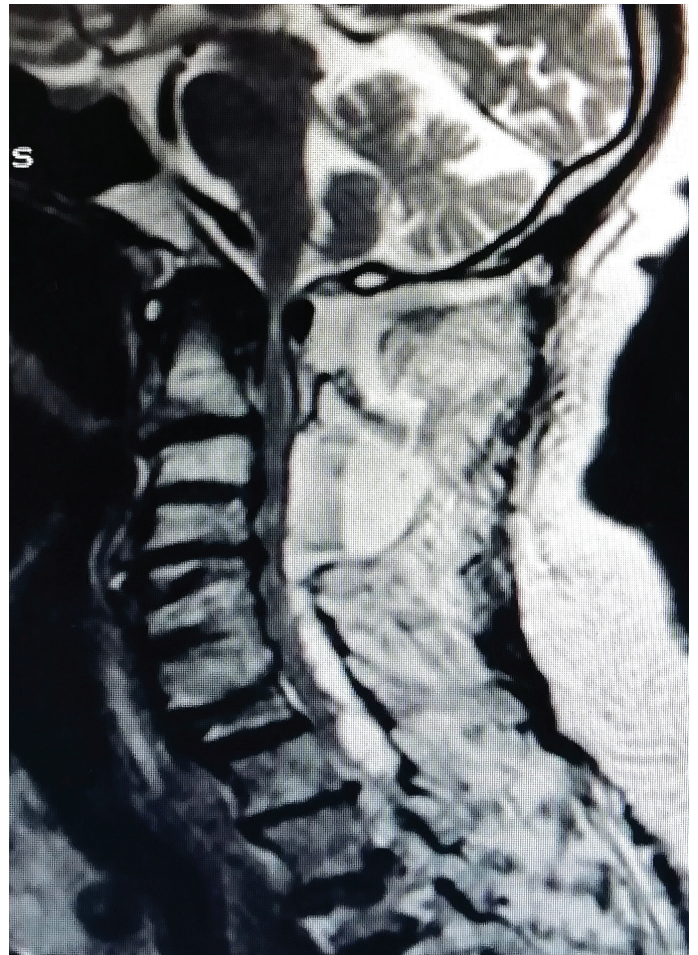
Postoperative cervical axial T2-weighted magnetic resonance imaging
